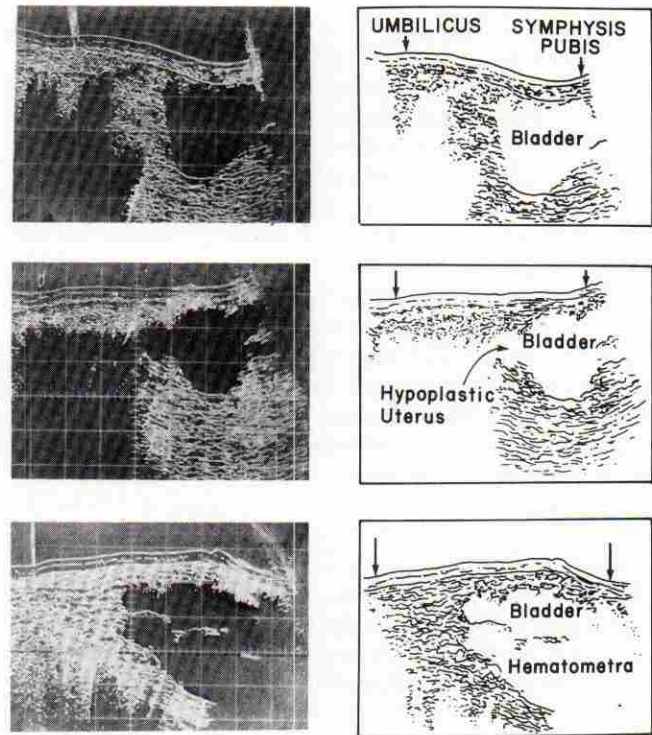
Results of sonographic examinations in three patients with congenital absence of the vagina demonstrating the variability of the uterine remnant. Representative midline longitudinal cross sections are shown. Top. Patient 4, in whom no uterine remnant was demonstrable; Middle. Patient 1, in whom solid uterine remnant was present; Bottom. Patient 7, in whom the uterine remnant contained a hematometra.
